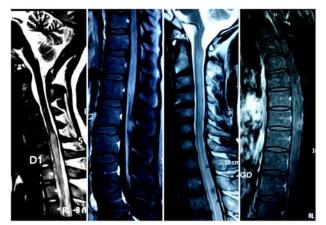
MRI cervical spine T2 image shows long segment intramedullary lesion (First & third image ). Contrast MRI Lumbar & Thoracic spine show conglomerate ring enhancing spinal tuberculoma (Second and Fourth image)
